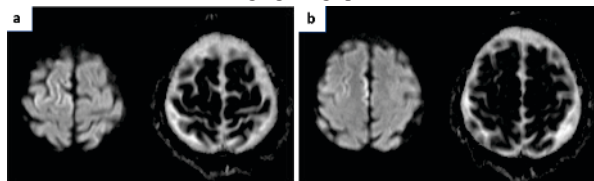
a) and b) DWI and ADC shows gyriform diffusion restriction involving right high parietal lobe (Cortical Ribbon sign) and right superior frontal gyrus.
